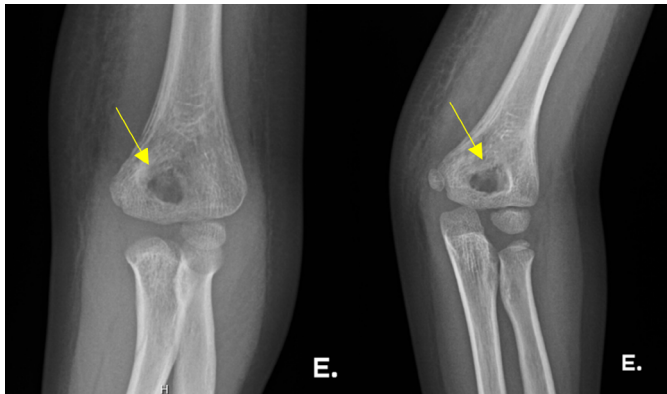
Radiograph of the elbow with periosteal reaction in the left distal humerus.
